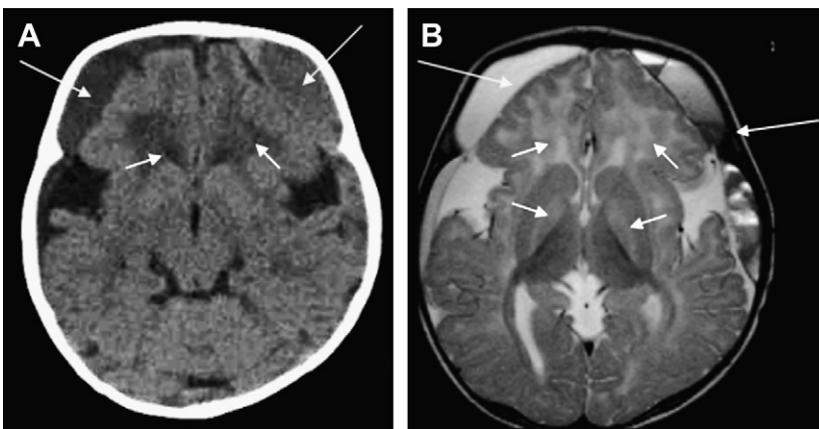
Twelve-month-old infant with triad and alleged NAI. Glutaric acidopathy type 1. CT (A) and T2 MR imaging (B) shows bilateral SDH of varying age (long arrows), wide sylvian fissures plus basal ganglia, and cerebral white matter abnormalities (short arrows).
